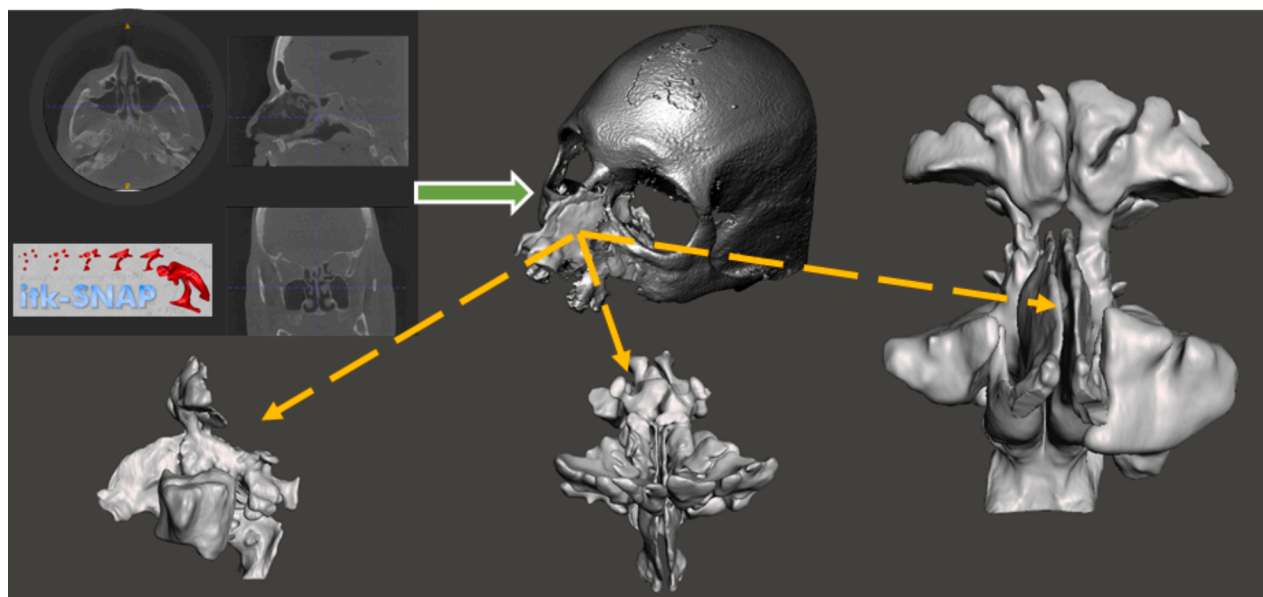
Reconstruction model from CT scans using open-source software (ITK-SNAP).
